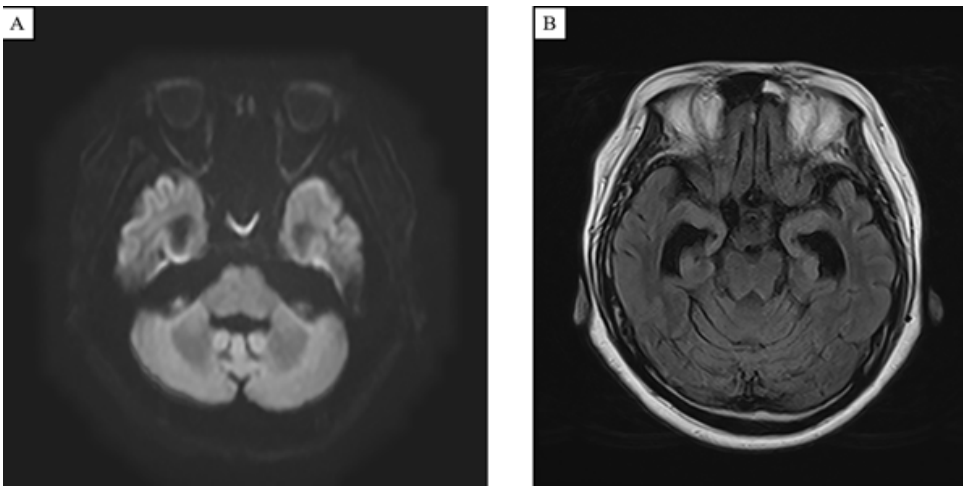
(A) The high-signal areas in the middle cerebellar peduncles observed on diffusion-weighted MRI of the head have disappeared. (B) The sulci that had disappeared on the FLAIR image of the head MRI normalized, suggesting an improvement in brain edema.
